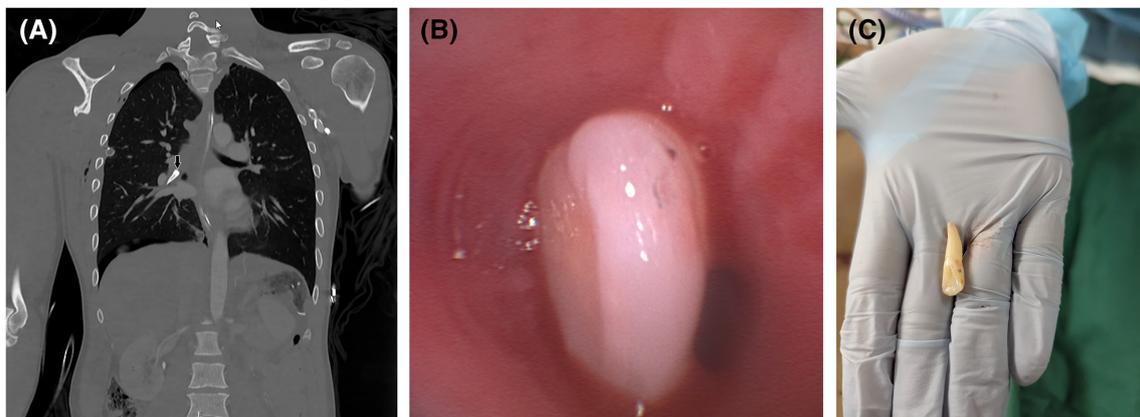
Panel (A): Computed tomography (CT) scan showing an aspirated tooth (arrow) located in the right lower lobe bronchus. Panel (B): Bronchoscopic view of the aspirated tooth lodged in the anterior segment of the right lower lobe bronchus. The tooth is visible within the bronchial lumen, obstructing the airway. Panel (C): The retrieved tooth.
